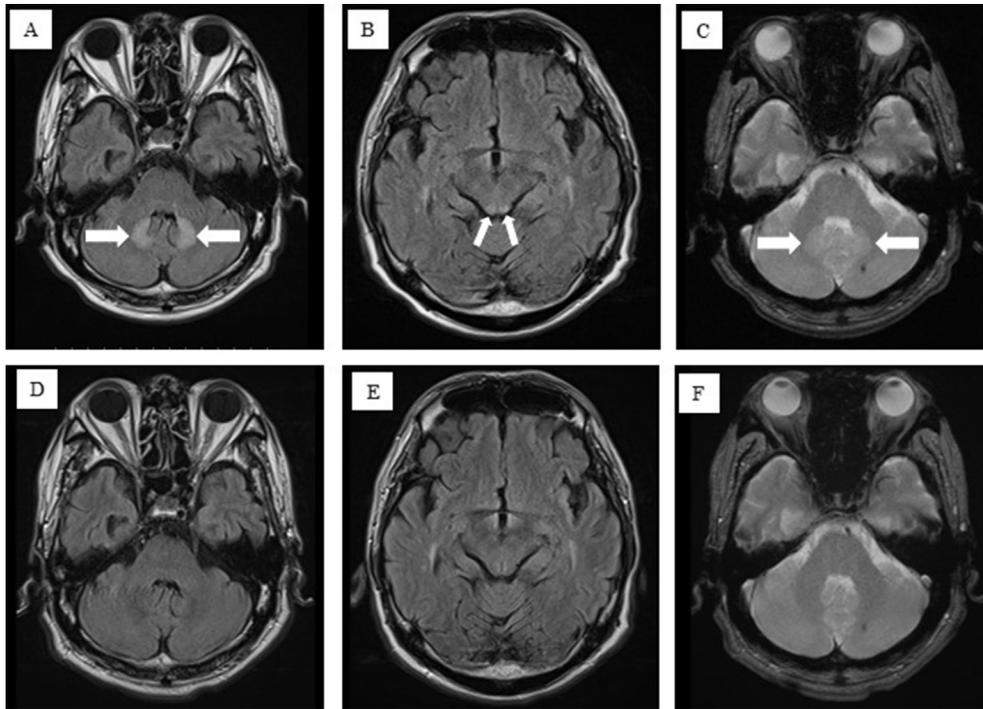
Shows an axial brain MRI. (A, B, D, E) Fluid-attenuated inversion recovery and (C, F) T2-weighted image. (A, C, D, and F) cerebellar dentate nucleus and (B, E) mid-brain tegmentum. (A–C) MRI showing high-intensity areas (white arrows) at 2 days of hospital visit. (D–F) Complete resolution of high-intensity areas at 32 days of metronidazole discontinuation.
